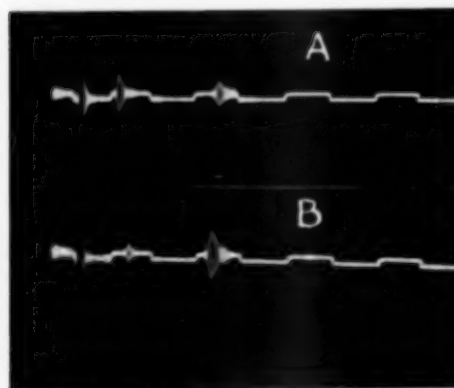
(Mundt and Hughes). (A) Normal ultrasonic tracing of a normal eye. (B) Tracing of the opposite eye of the same patient which contained a malignant melanoma near the posterior pole.
